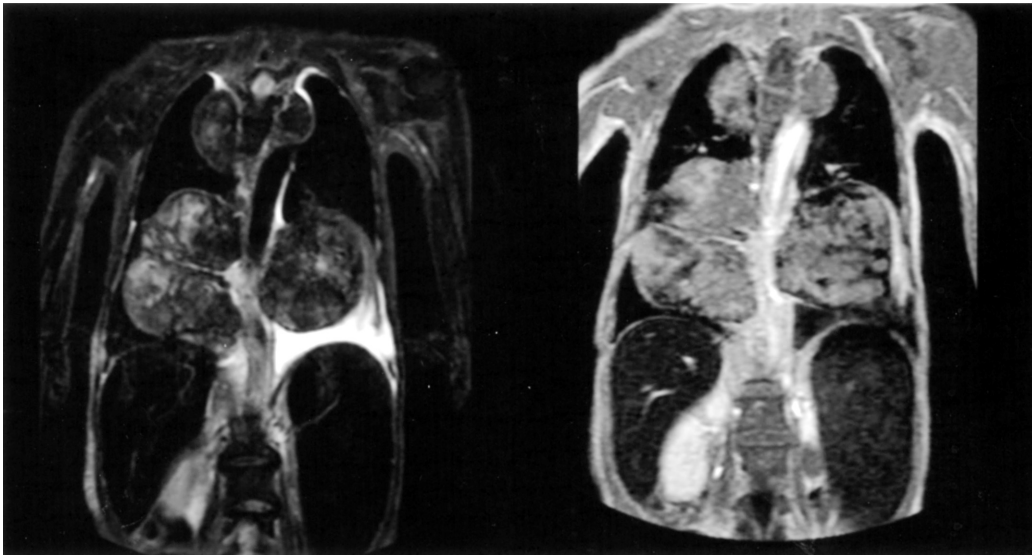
Magnetic resonance imaging reveals well-demarcated heterogenous enhanced soft tissue masses at the mediastinum and bilateral pleural spaces, which showed heterogenous iso to low signal intensity on T1W1 and hyper-intensity on T2W1.
